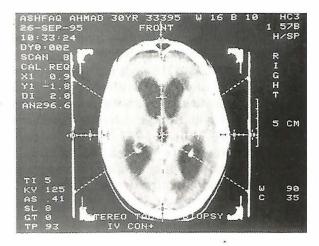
Preoperative axial CT scan showing deep seated midline abscess with target localization.
